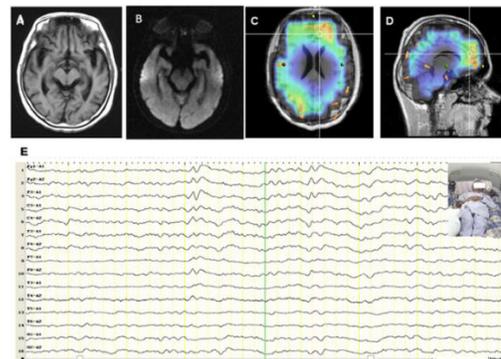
MRI, EEG and spike sLORETA analysis presentations of the patient. The patient presented normal MRI in T2 flare and DWI sans (A,B); slow and accidental sharp and slow wave complex in bifrontal and biparietal leads with diffuse theta and delta wave background during FBDS (E), sLORETA (Standardized low-resolution brain electromagnetic tomography)
